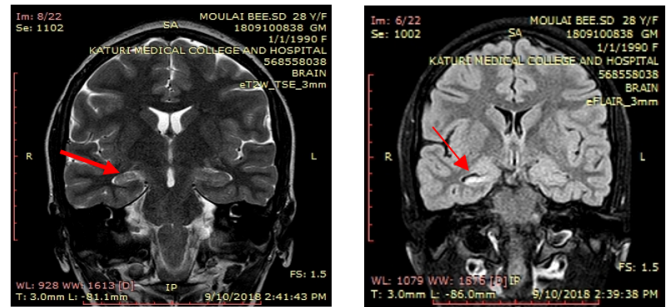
A & B - Coronal T2W & Coronal FLAIR images showing hyperintense signal, reduction of volume and loss of digitations in right hippocampus (arrows).
